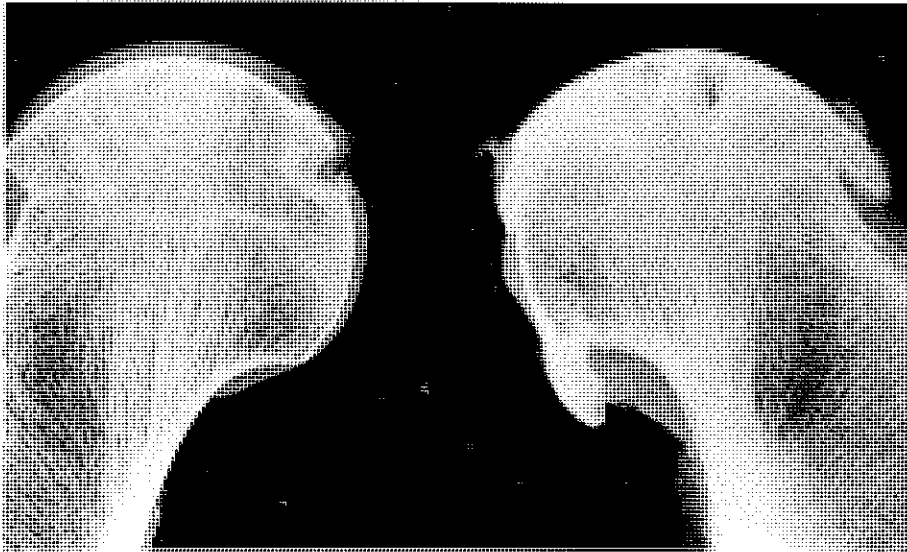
X-ray of hip showing normal cartilage (L) and loss of cartilage and osteophyte formation (R)
